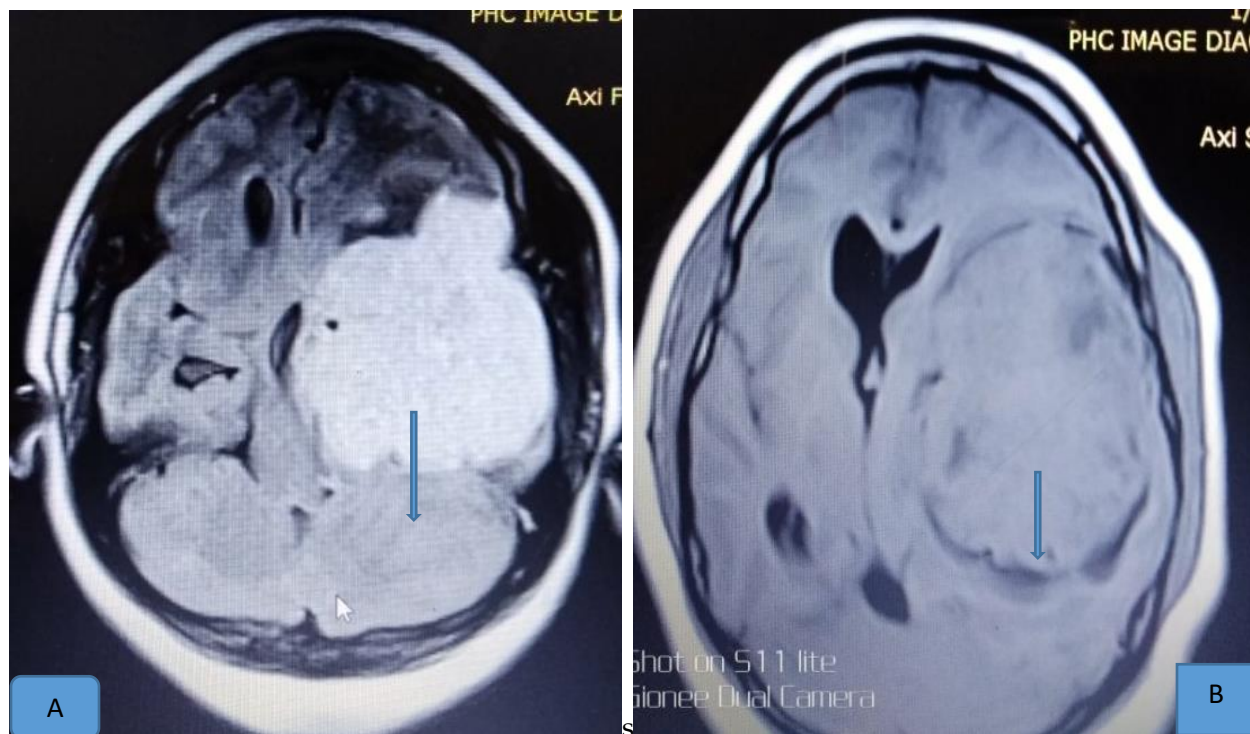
T1W (A) and FLAIR (B) MRI images of the brain showing a large heterogeneous mass arising from the left temporal lobe due to cerebral glioma.
